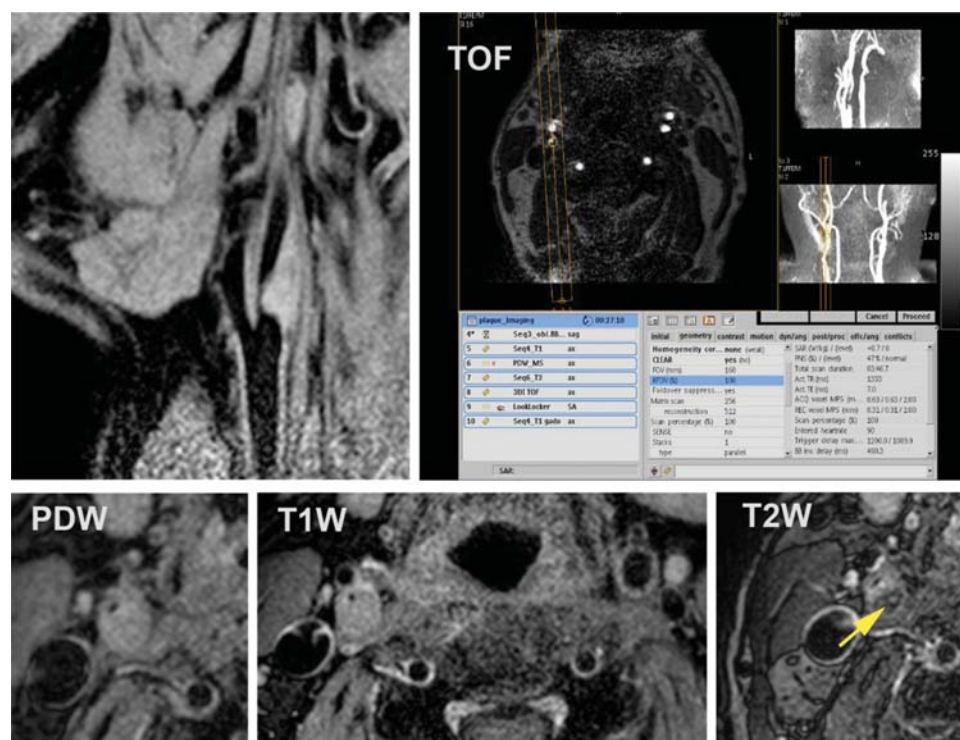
Magnetic resonance imaging examination of carotid atherosclerotic plaque in a patient with symptomatic carotid disease. An echo sequence is used to localize the carotid bifurcation (upper panel, left) and time-of-flight (TOF) sequence allows the definition of the stenosis without needing contrast injection (upper panel, right). Multisequence high-resolution magnetic resonance demonstrates the presence of a severely stenotic plaque with a large lipid core (yellow arrow in T2W image) (published with the permission of Prof. Dr A. Gallino and Dr R. Wytenbach, Bellinzona, Switzerland).
